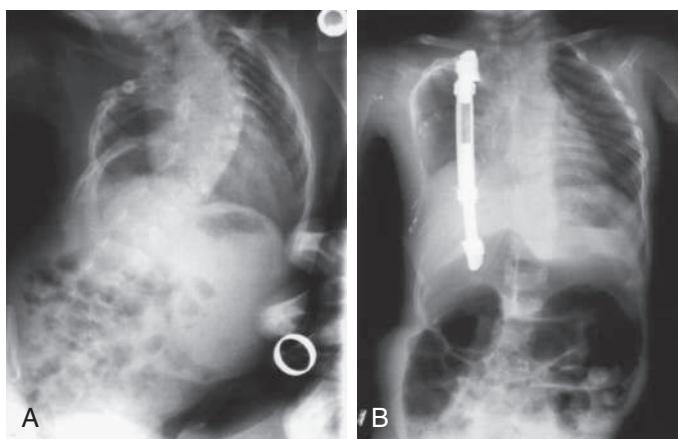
A, Anteroposterior preoperative radiograph of a 7-mo-old infant with congenital scoliosis and fused ribs. A three-dimensional reconstruction of a CT scan of the chest of this infant estimated his lung volume to be 173.2 mL^3 . B, Anteroposterior radiograph after implantation of a vertically expandable prosthetic titanium rib and several expansions over 33 mo. The lung volume now measures 330.3 mL^3 , an increase of 90.7%. (From Gollogly S, Smith JT, Campbell RM. Determining lung volume with three-dimensional reconstructions of CT scan data: a pilot study to evaluate the effects of expansion thoracoplasty on children with severe spinal deformities. *J Pediatr Orthop.* 2004;23:323-328.)
